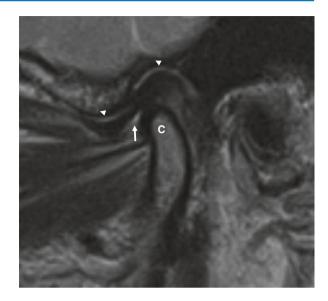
Normal disc position and configuration with the posterior band (arrow) being anterior to the 12 o'clock position relative to the condyle, but the relationship between the central thin zone to the anterior prominence of the condyle (arrowhead) and the posterior prominence of the articular tubercle (arrowhead) is normal. These and all subsequent MR images were acquired at 1.5 T field strength and are derived from the VA UCSF patient archive
